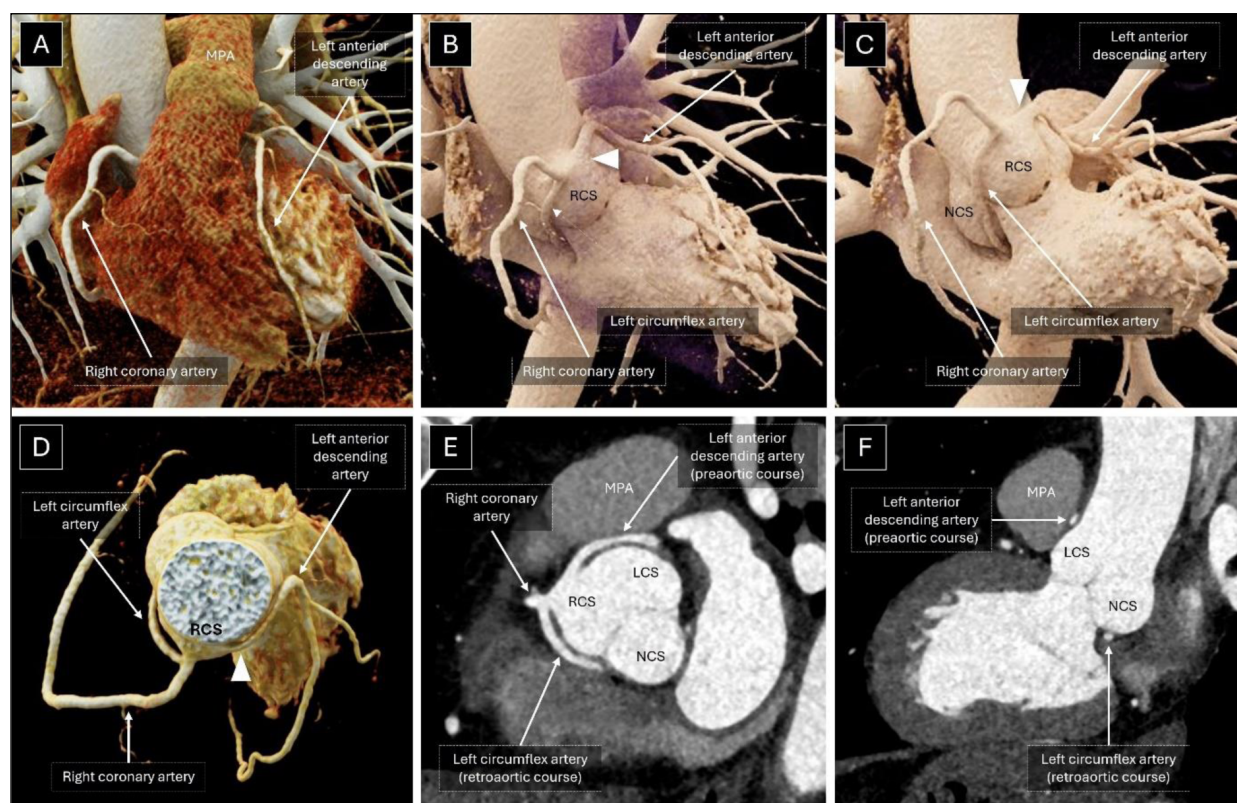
Volume-rendered images (A-D) of coronary computed tomography angiography shows normal origin and course of the RCA. Note the anomalous origin of the LCx from the proximal RCA, taking a retroaortic course to reach the left atrioventricular groove. The LAD artery (white arrowhead) is seen arising from the RCS, adjacent to the RCA ostium, taking a pre-aortic, interarterial course (between the aorta and MPA) to reach the anterior interventricular groove. A short axis reconstruction (E) at the level of the aortic root and an oblique sagittal reconstruction (F) demonstrate the unique circum-aortic (retroaortic and preaortic) configuration of the left coronary arteries (LCx and LAD arteries respectively). MPA: main pulmonary artery; LCS: left coronary sinus; NCS: non-coronary sinus; RCA: right coronary artery; LAD: left anterior descending; RCS: right coronary sinus; LCx: left circumflex
